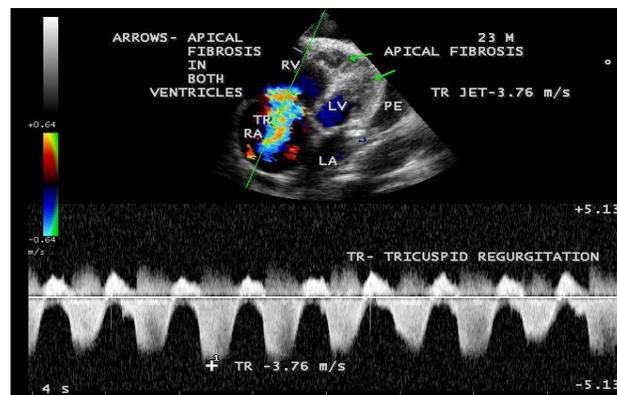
Parasternal long axis view showing RV (right ventricular) apical fibrosis suggesting EMF (endomyocardial fibrosius) in a 23-year-old male with tuberculosis
